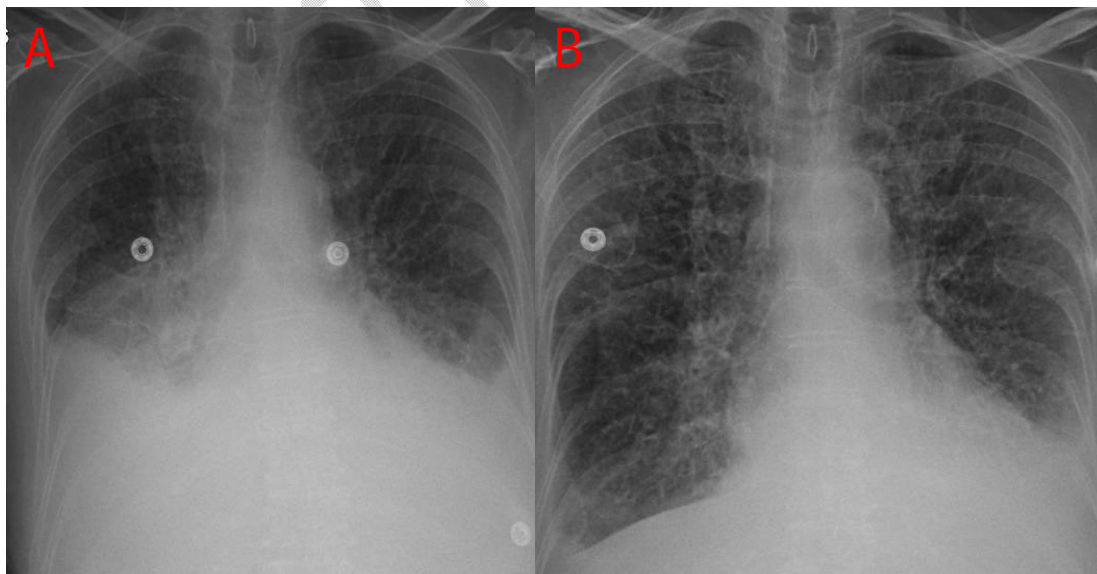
chest X-ray: A- showing recurrent moderate to abundant pleural effusion of the right lung. B- showing regressed pleural effusion post pleural puncture with persistent interstitial syndrome.
